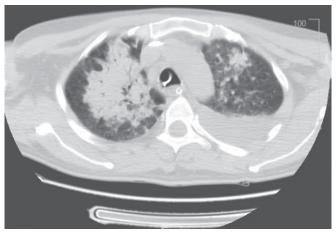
A repeat high resolution computed tomography chest done at 3rd week of admission showing multifocal peribronchial consolidations and effusion suggestive of diffuse alveolar hemorrhage with clinical settings of hemoptysis
